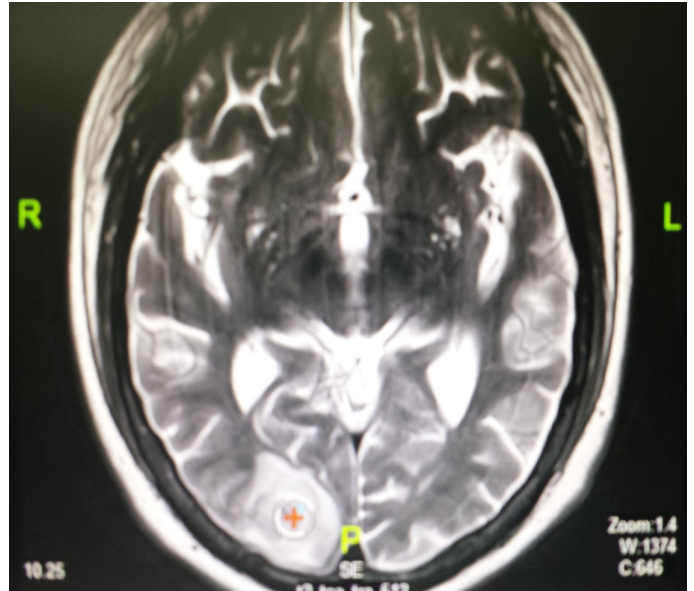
MRI of the brain showing right occipital infarct.
